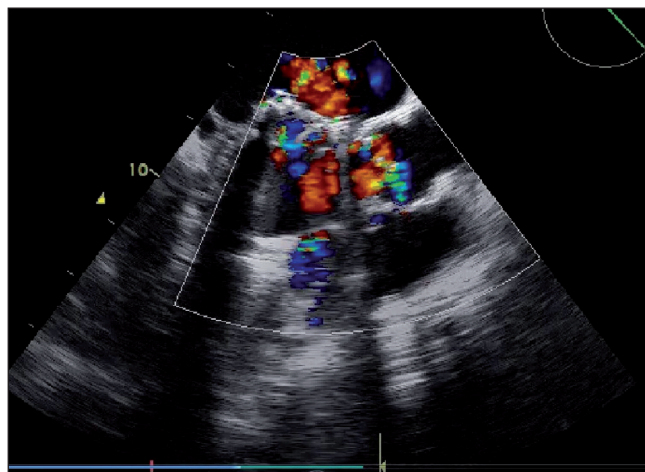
Echocardiography showed moderate paravalvular leak, bilateral mechanical prosthetic valves, and a clot in antero-medial of sewing ring.
